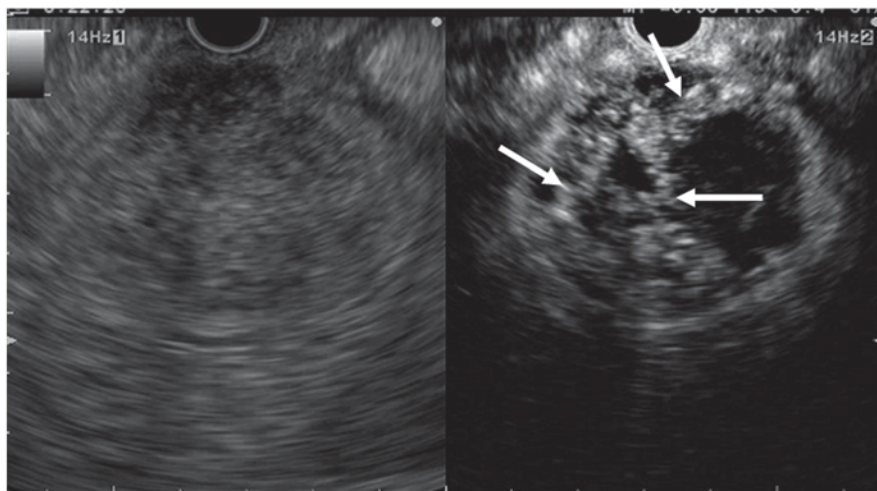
Typical conventional (*left*) and contrast-enhanced harmonic (*right*) EUS images of the gastrointestinal stromal tumor. Conventional EUS (*left*) shows a tumor (*arrowheads*) of 4 cm in diameter in the fourth layer of the gastric wall. Contrast-enhanced harmonic EUS (*right*) revealed irregular vessels (*arrows*) in the tumor. *EUS* endoscopic ultrasonography
